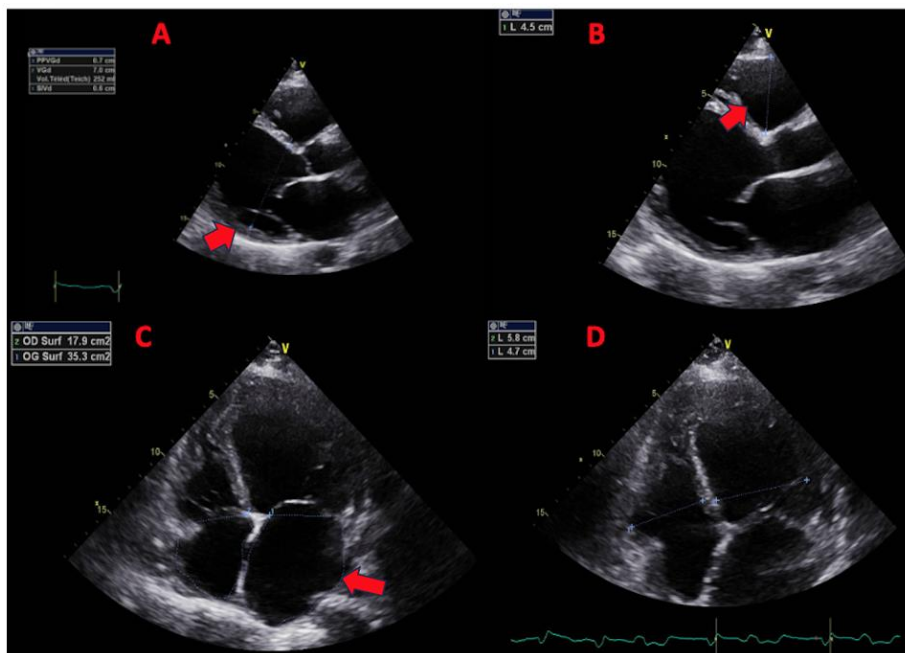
The echocardiography demonstrates biventricular enlargement
